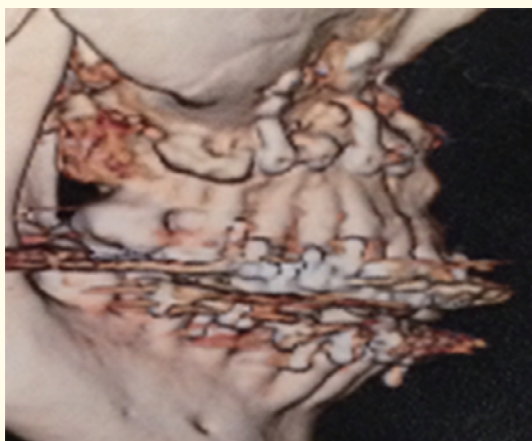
Three-dimensional computed tomography scan showing no bone gap and appropriate sealing of buccal bone wall of maxillary sinus.
